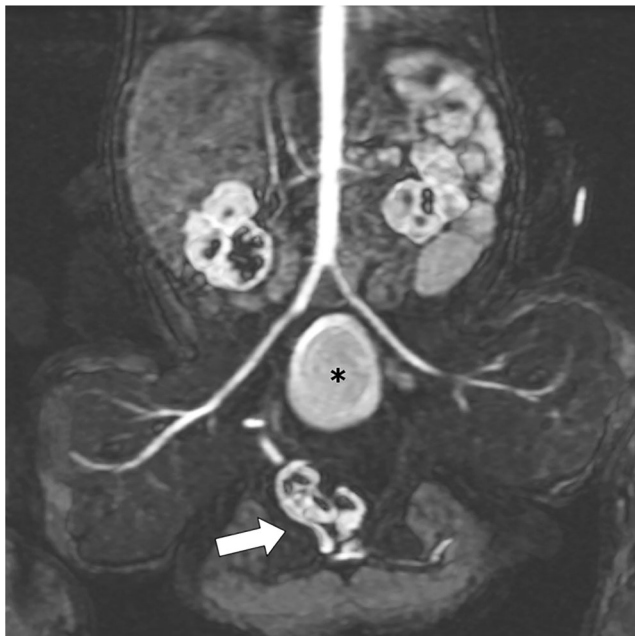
Coronal contrast-enhanced MRI of the abdomen of the neonatal ischiopagus parasiticus tetrapus. *Arrow* points at additional pelvic kidney. *Asterisk* marks the meconium-filled rectum
